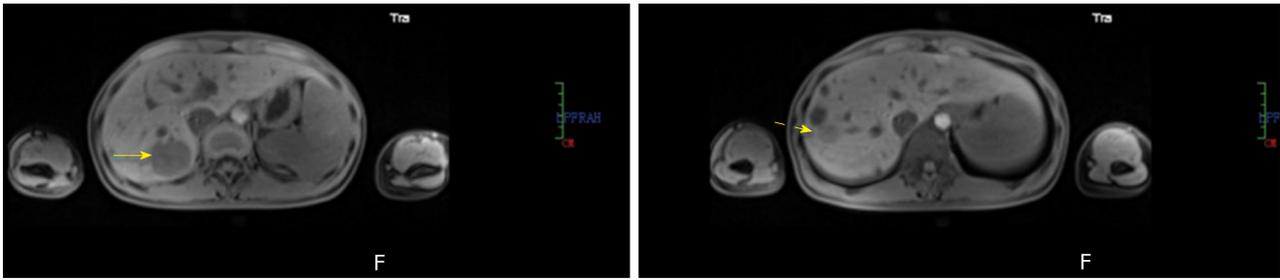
Magnetic resonance imaging. Two well-circumscribed lesions with long T1 and long or equal T2 signal (arrows). The multiple lesions with long T1 and long T2 signal are hepatic cysts verified by pathological examination later.
